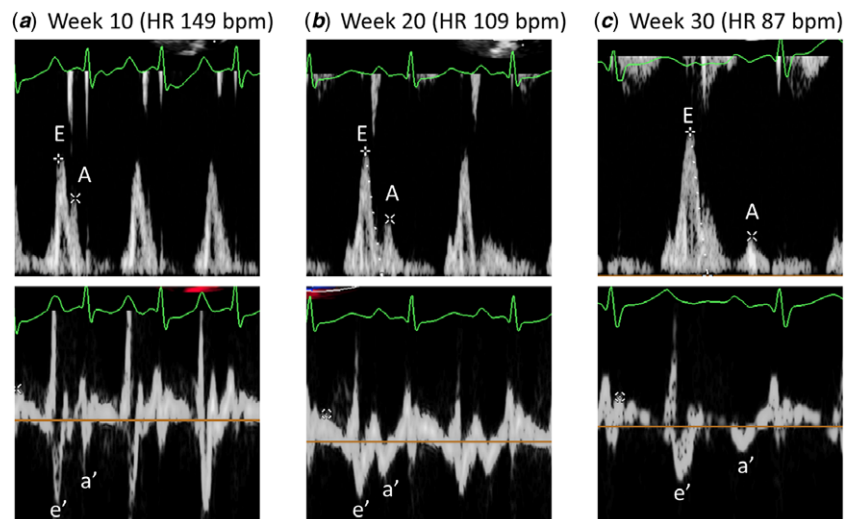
Echocardiography: Pulse-wave Doppler recordings of trans-mitral diastolic inflow filling velocities (upper panels) and tissue Doppler recordings of septal mitral annular velocities (lower panels) 10 (a), 20 (b), and 30 (c) weeks after hospitalization. Before administering ivabradine in week 13, E and A waves and e' and a' waves were not separated, and the diastolic time was short. As the heart rate decreased due to ivabradine administration, each waveform became separated and the diastolic time became prolonged.
